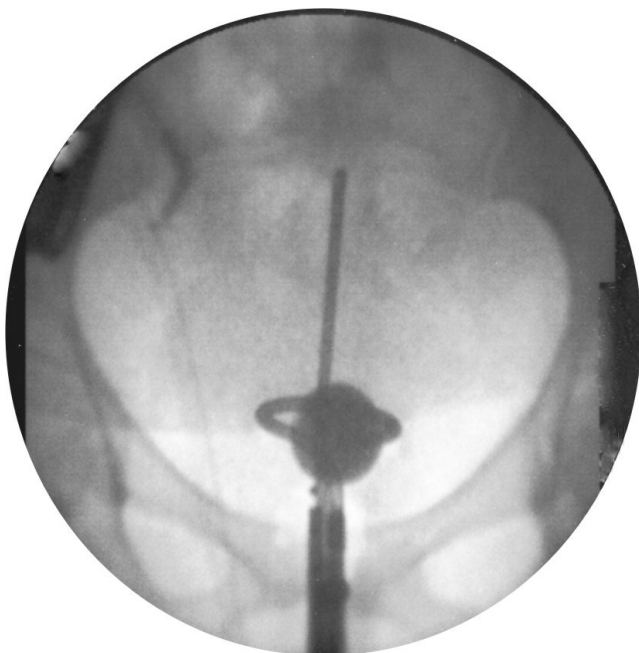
Anterior-posterior brachytherapy insertion radiograph
